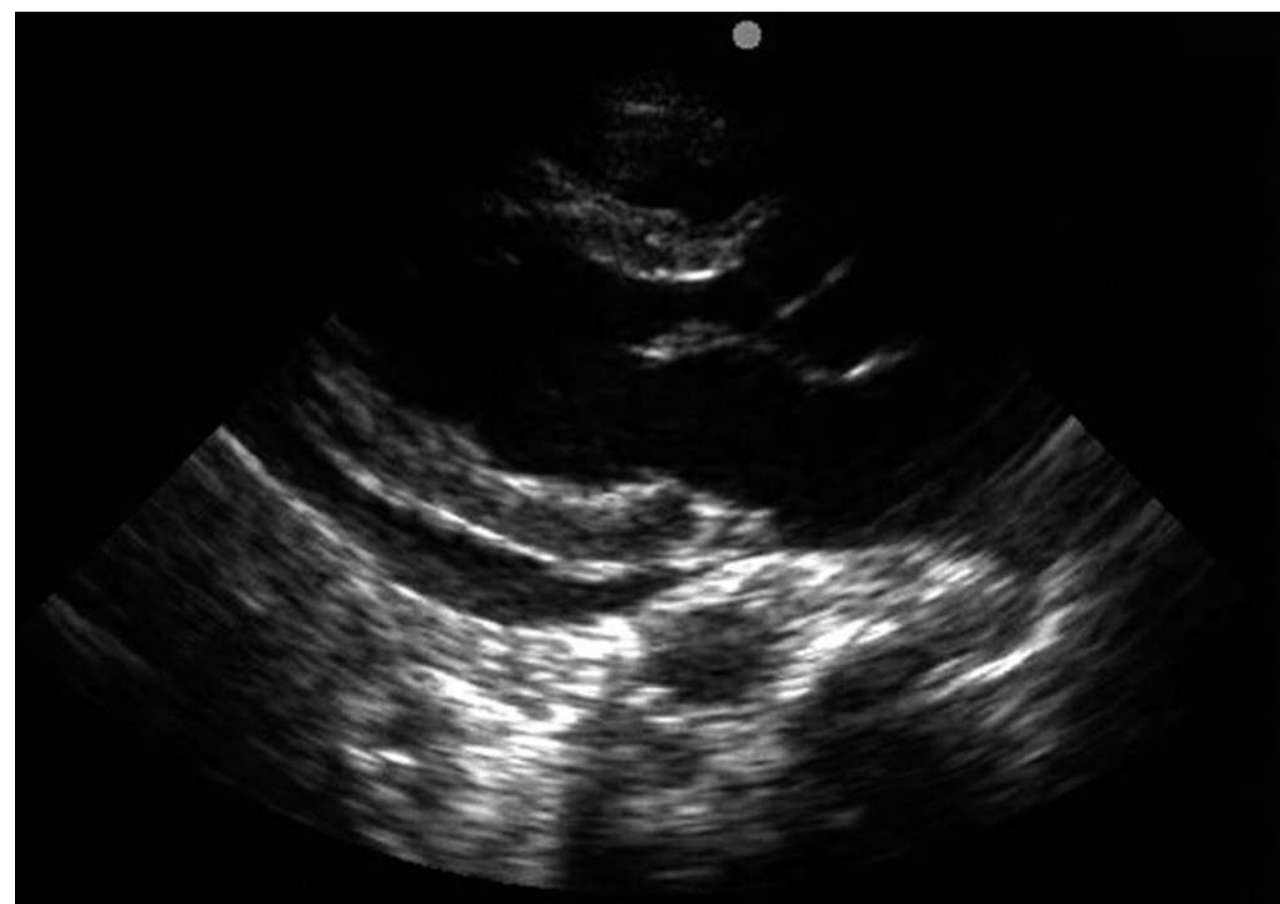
Parasternal long-axis view showing a moderate-sized pericardial effusion with an anechoic fluid stripe layering out posterior to the myocardium and anterior to the descending aorta.
